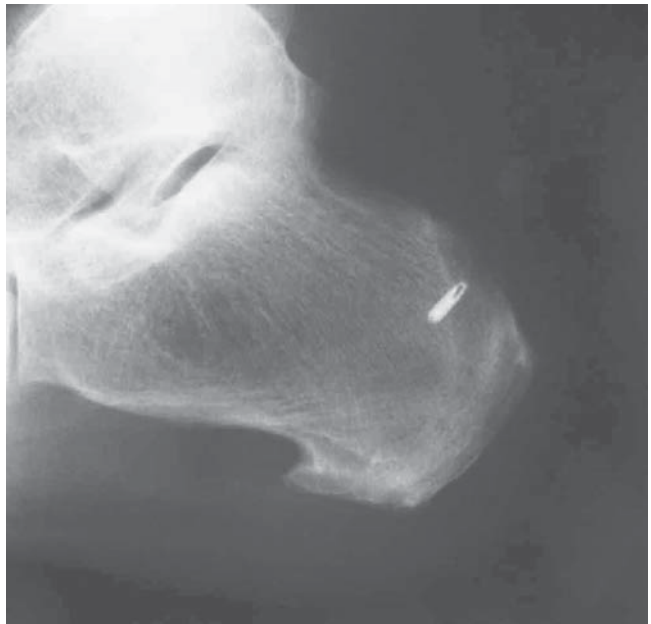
Postoperative radiograph with bone anchor in situ.
